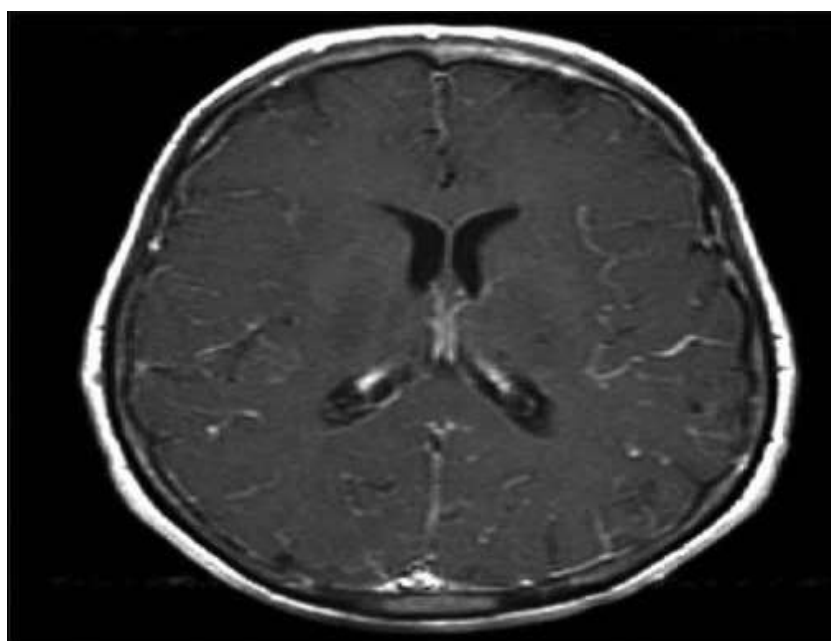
showing Contrast MRI Brain showing mild meningeal enhancement
